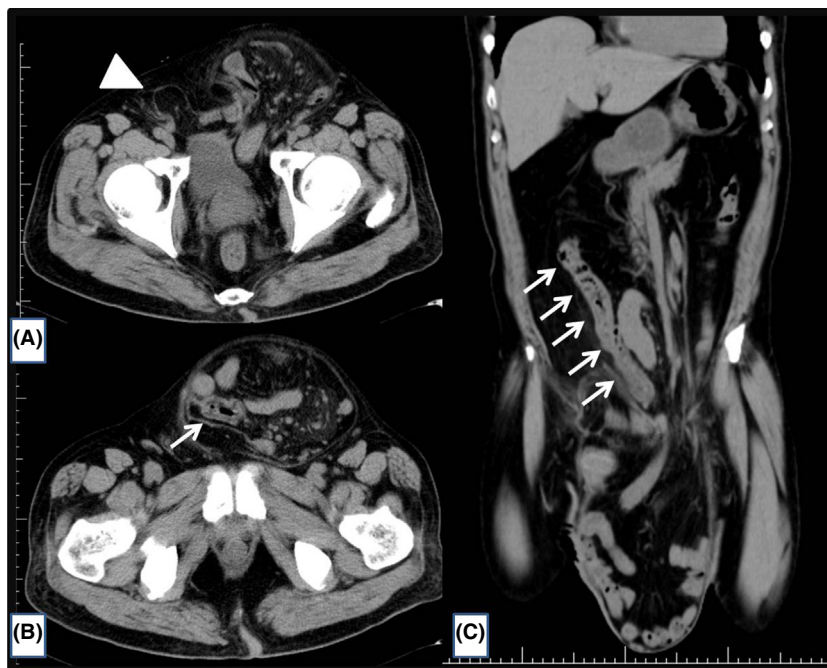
A computed tomography scan depicting dislocation of the ileum, appendix, cecum, and ascending colon (arrows) into a left-sided inguinoscrotal hernial sac, and a right-sided inguinal hernia (arrowhead).
